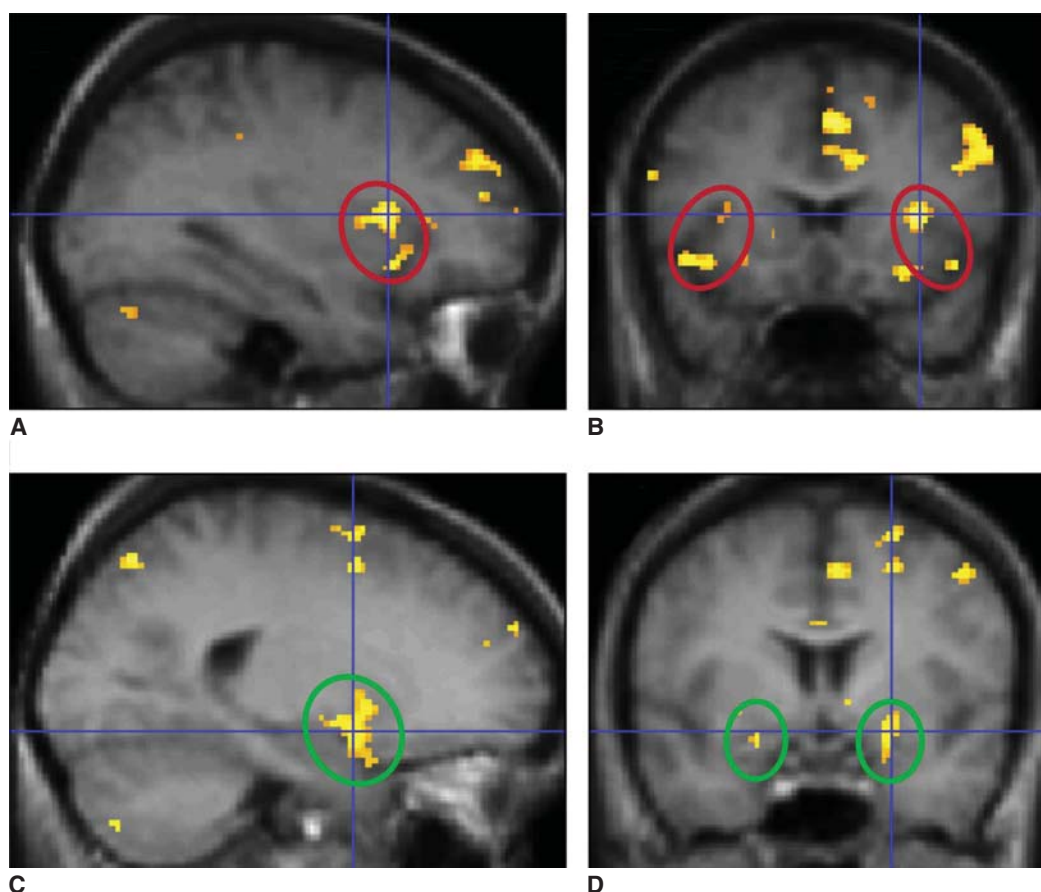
Functional brain images showing some important paralimbic activations during laboratory-induced air hunger (data from Evans et al²⁹). Air hunger was induced during volume-control ventilation by lowering tidal volume (V_T); red ovals in A and B indicate activations in the anterior insular cortex (IC). The sagittal section (A) is in the right hemisphere, 34 mm from the midline; the coronal section (B) is 16 mm forward of the anterior commissure. The anterior insula is also involved in hunger, thirst, and pain. Green ovals in C and D indicate activations in the amygdala. The sagittal section (C) is in the right hemisphere, 24 mm from the midline; the coronal section (D) is 4 mm forward of the anterior commissure. The amygdala is implicated in states of fear and anxiety. These images were obtained using blood oxygen level dependent functional magnetic resonance imaging. All activations shown were statistically significant after correction for multiple comparison.
